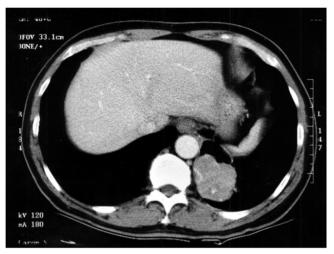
Computed tomography scan revealing a large mass on the medial aspect of the left lower lobe
